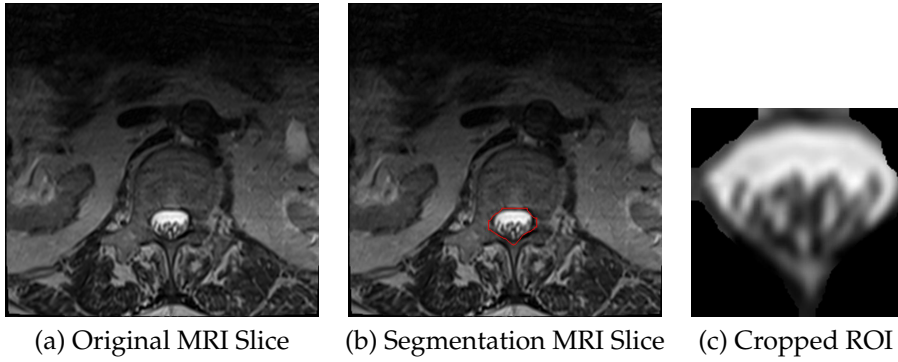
Example of segmentation process: original axial MRI slice (a), YOIO segmentation (b) and cropped lumbar spine region (c).
